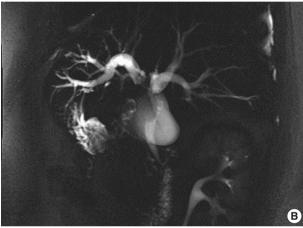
(A) Computed tomography reveals perihilar cholangiocarcinoma with metastatic lymph nodes. (B) Magnetic resonance cholangiopancreatography shows strictures of the left intrahepatic duct to common hepatic duct.
